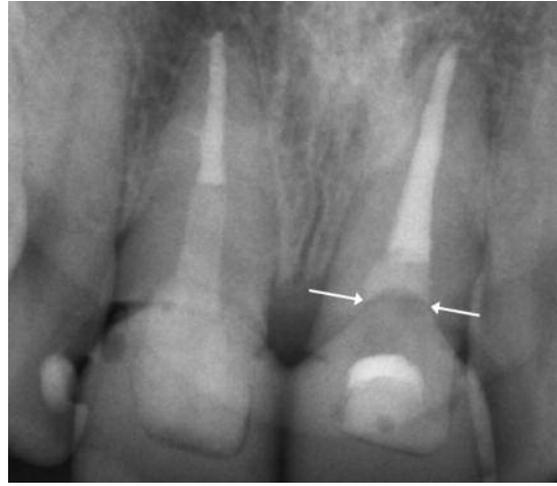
X-ray examination after root canal obturation and glass fibre post insertion in tooth 11 and revision of 21; the root canal filling was covered with a glass ionomer cement before internal bleaching (3% H₂O₂ and sodium perborate) was applied.
